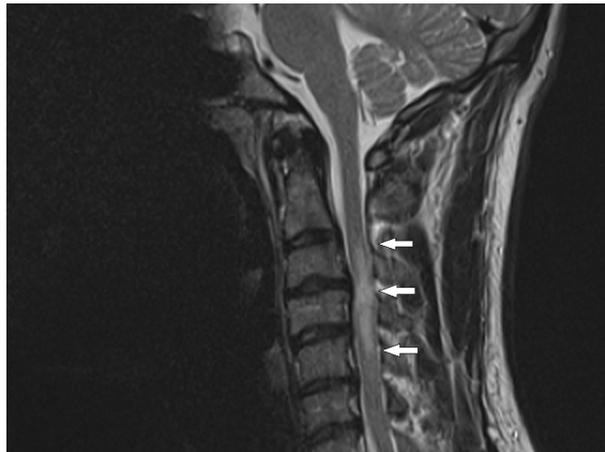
36-year-old male, presenting with numbness in both arms and cervical pain. MRI showed a cervical myelitis (C3-C5, arrows). Bilateral mediastinal lymphadenopathy was seen on a chest X-ray and the diagnosis sarcoidosis was confirmed with an endobronchial ultrasound fine-needle aspiration (EBUS-FNA).
